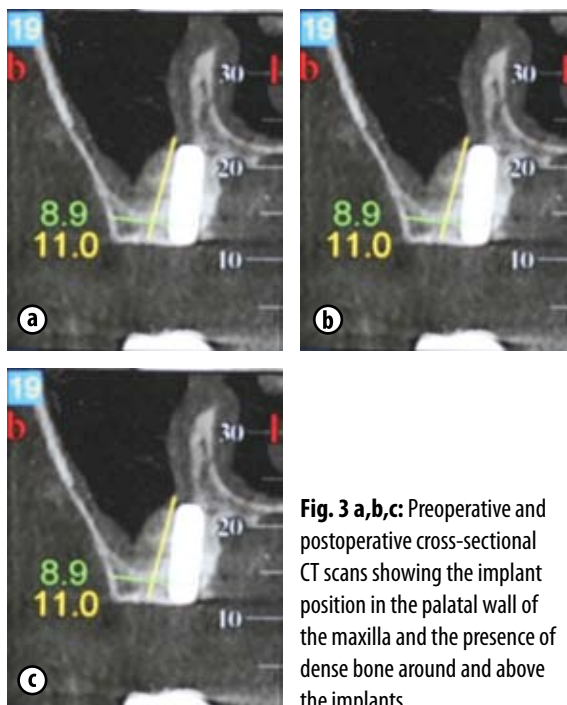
a,b,c: Preoperative and postoperative cross-sectional CT scans showing the implant position in the palatal wall of the maxilla and the presence of dense bone around and above the implants.
